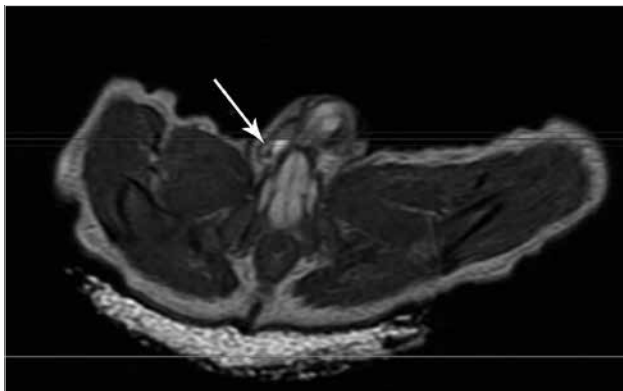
Axial MR image. The right testicle in the normal localization, the right testicular vessels, and the ductus structures are monitored in the right inguinal canal.
